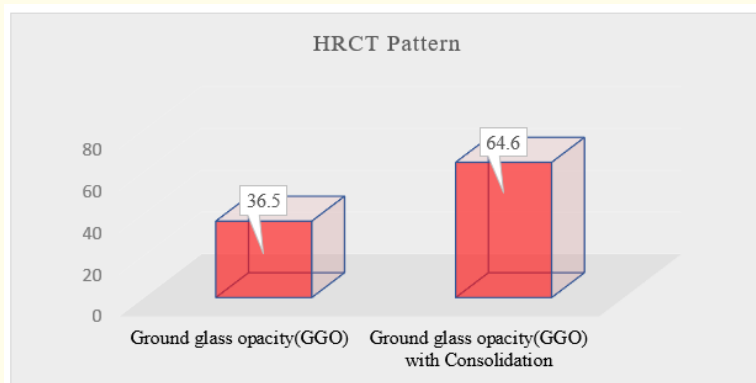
HRCT pattern of the patients (N = 46).
